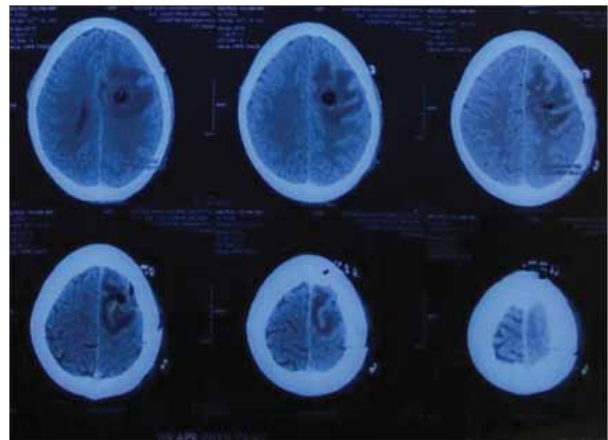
CT-scan of Brain (08 Apr 2019) showing edematous changes containing air densities in left fronto-parietal region.
